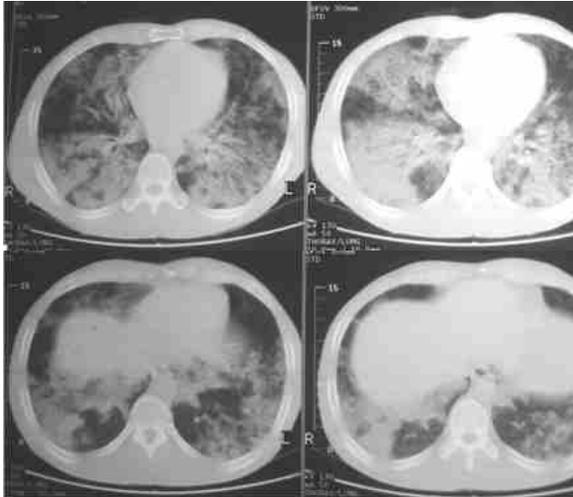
CT Scan chest showing fine reticular pattern superimposed on areas of ground-glass opacity
